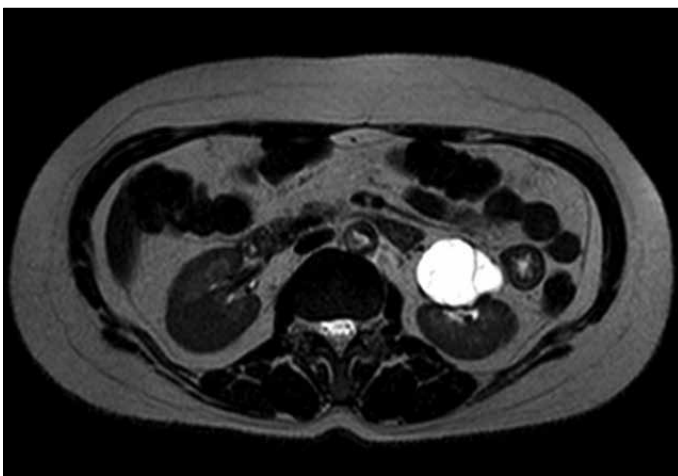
Cystic lesion with contrast-enhanced septae, and cystic walls in magnetic resonance imaging
